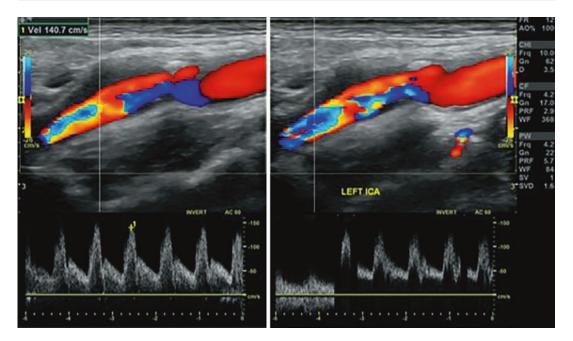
Carotidynia where there are flow disturbances in the section of the carotid that has the problem with the use of color Doppler parallel to the course of the artery
